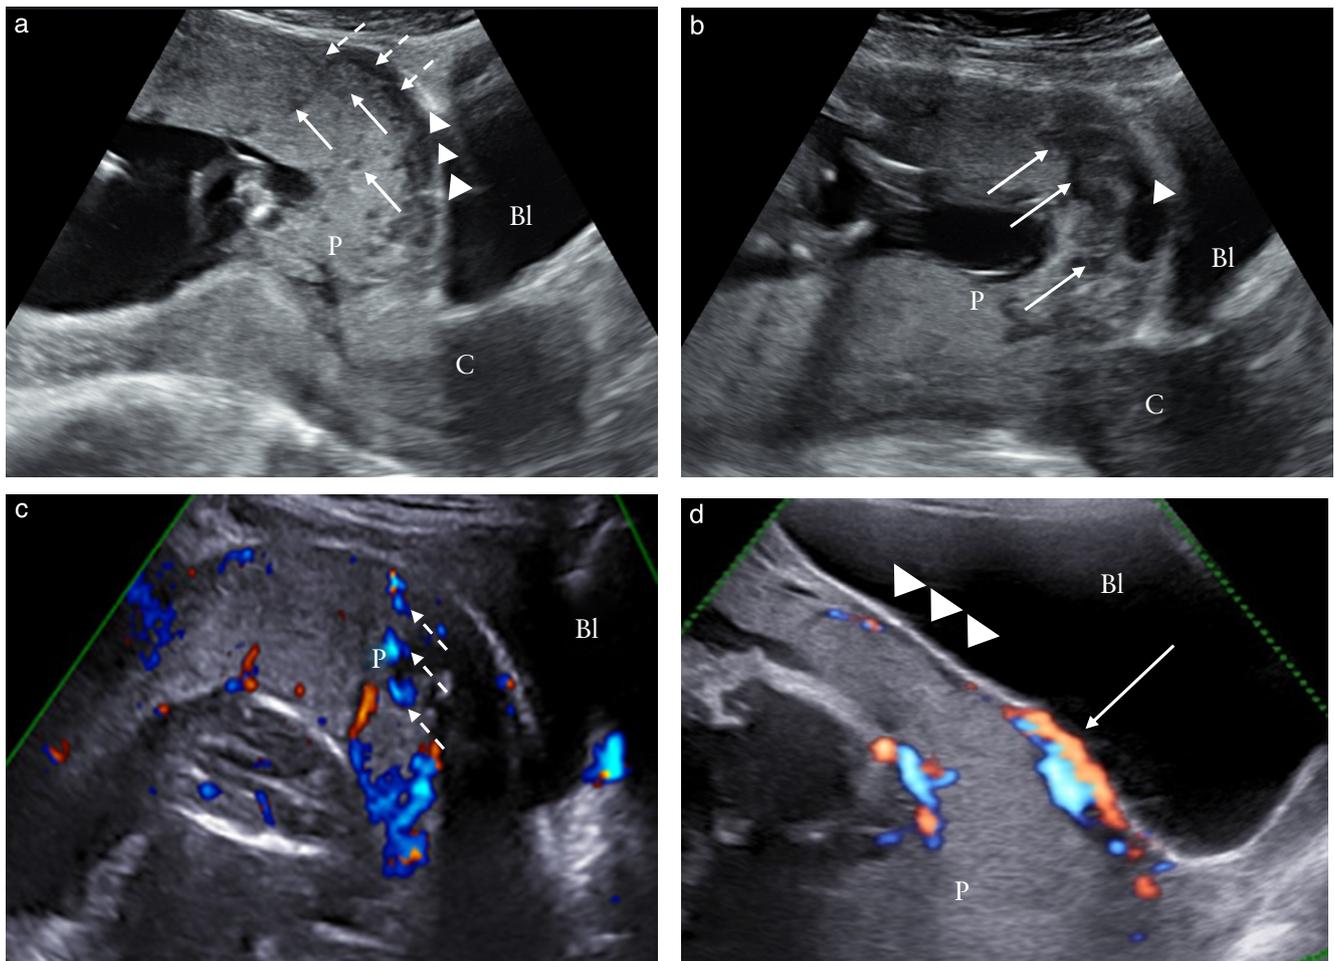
Ultrasound signs of abnormally invasive placenta in first trimester of pregnancy (11–14 weeks' gestation). (a) Transabdominal ultrasound (TAS), showing anterior placenta (P) previa, in which several hypoechoic round areas (placental lacunae) can be detected in placental parenchyma (arrows) and irregularity of hypoechoic plane beneath placental bed (loss of clear zone) is present (dotted arrows), as well as interruption of hyperechoic line between uterine serosa and bladder (Bl) lumen (bladder wall interruption, arrowheads). (b) TAS at 13 weeks, showing placenta implanted above internal cervical os (major previa), in which several placental lacunae (arrows) and interruption of bladder wall can be detected. (c) Color Doppler imaging, showing presence of blood flow within lacunae (dashed arrows). (d) Color Doppler imaging, showing presence of blood flow at level of bladder wall (arrow); irregularity of retroplacental clear zone is also visible (arrowheads). C, cervix.
